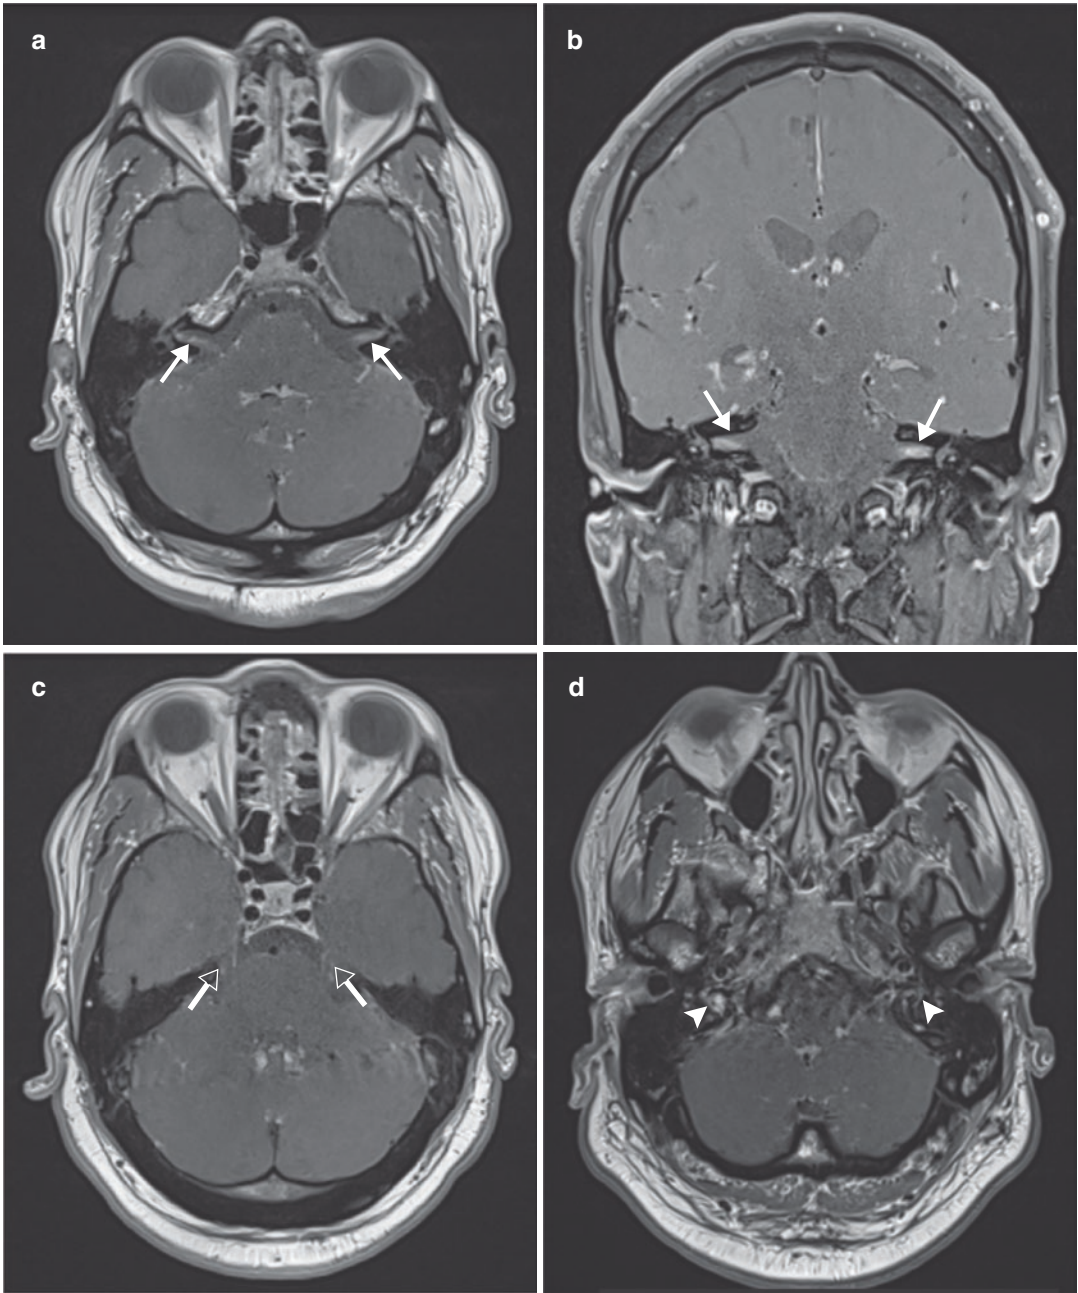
Cranial nerve involvement in tuberculosis. (a) Axial and (b) coronal contrast-enhanced T1-W MR images show bilateral nodular thickening of the seventh cranial nerves (white solid arrows). (c and d) Coronal
